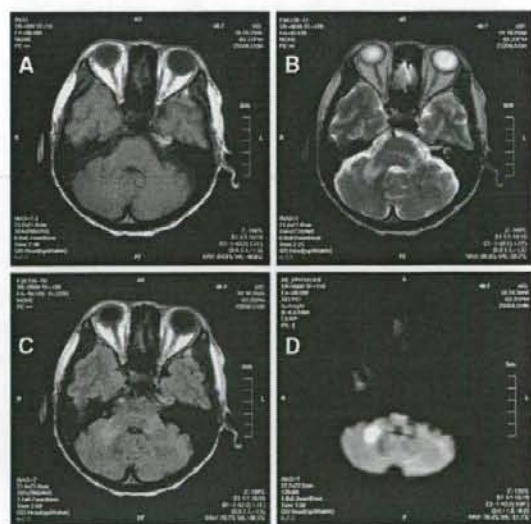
October 2006: magnetic resonance imaging showing mild cerebellar atrophy in a T1-weighted image (a), white matter abnormality in a T2-weighted image (b), white matter abnormality in fluid-attenuated inversion recovery (c), and intracellular edema in a diffusion-weighted image (d)
